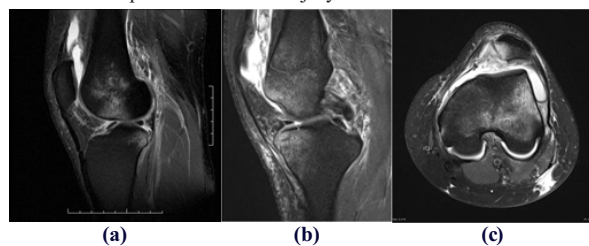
MRI images showing different types of bone bruise pattern; (a) pivot shift injury, (b) kissing contusions in hyperextension injury, (c) bruises in lateral patellar dislocation
